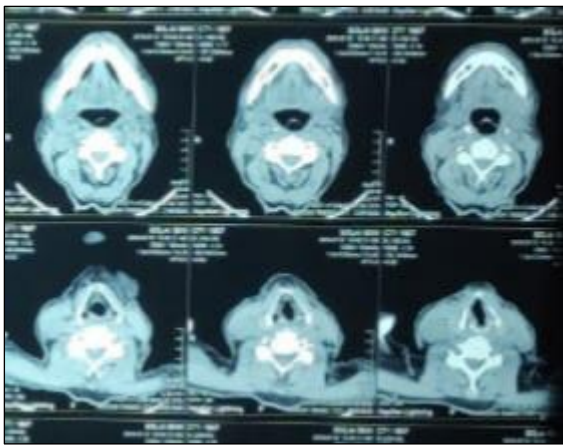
CT picture of case report 2.
